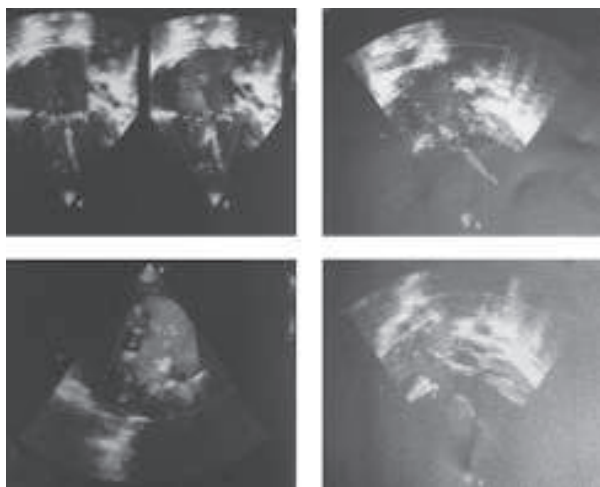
Doppler Eco-cardiogram of AVSD
